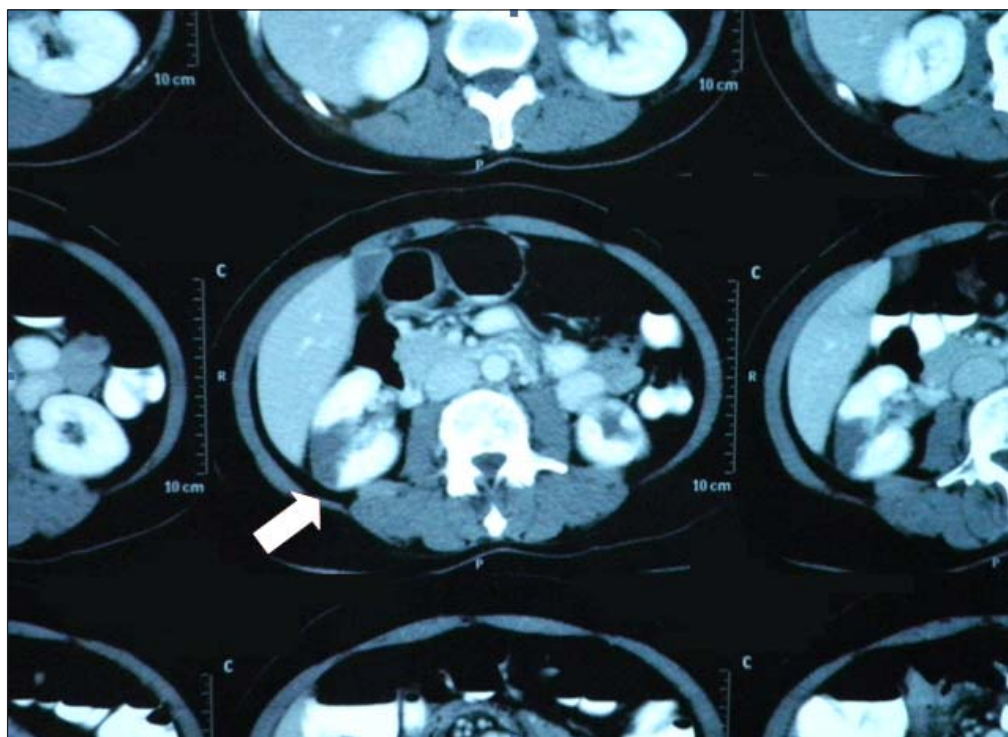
Abdominal computed tomography revealed: a hypodensity wedge-shape lesion at right kidney is compatible with renal infarction (arrow).
